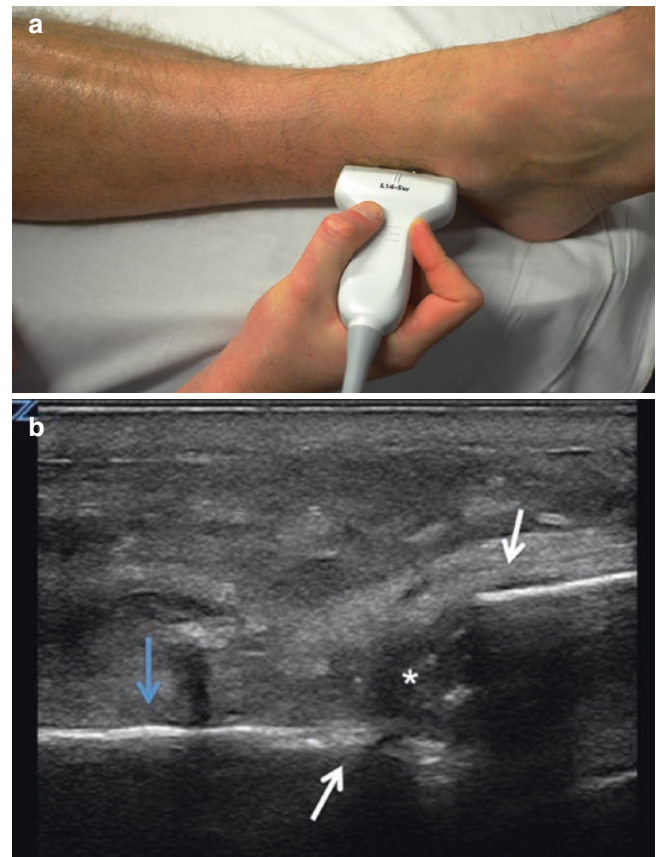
(a) When looking for fractures, a linear array probe should be used in the standard fashion, with the probe marker towards the patient's head to obtain a longitudinal view. Scan proximal from the area of deformity distally while correlating physical exam findings with ultrasound images, noting any cortical step-offs or deformities of the normal, smooth echogenic cortex of the bone. (b) A longitudinal view of a lateral malleolus fracture denoted by an apparent step-off (*white arrows*) of the normal smooth, echogenic cortex (*blue arrow*). An isoechoic and hypoechoic traumatic hemorrhage adjacent to the cortical step-off (*asterisk*) can be an additional sign to identify an acute fracture
